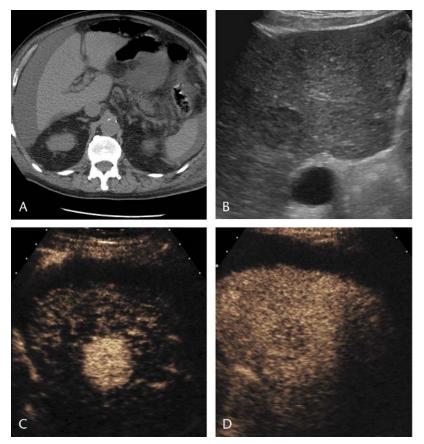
A, Nonenhanced CT performed on an 84-year-old man with renal failure and increasing abdominal girth. There is ascites. The liver is small. There is no focal mass shown. B, There is a focal indeterminate hypoechoic liver mass. C, There is arterial phase hyperenhancement. D, At 5 minutes, there is delayed weak washout, diagnostic of HCC.
